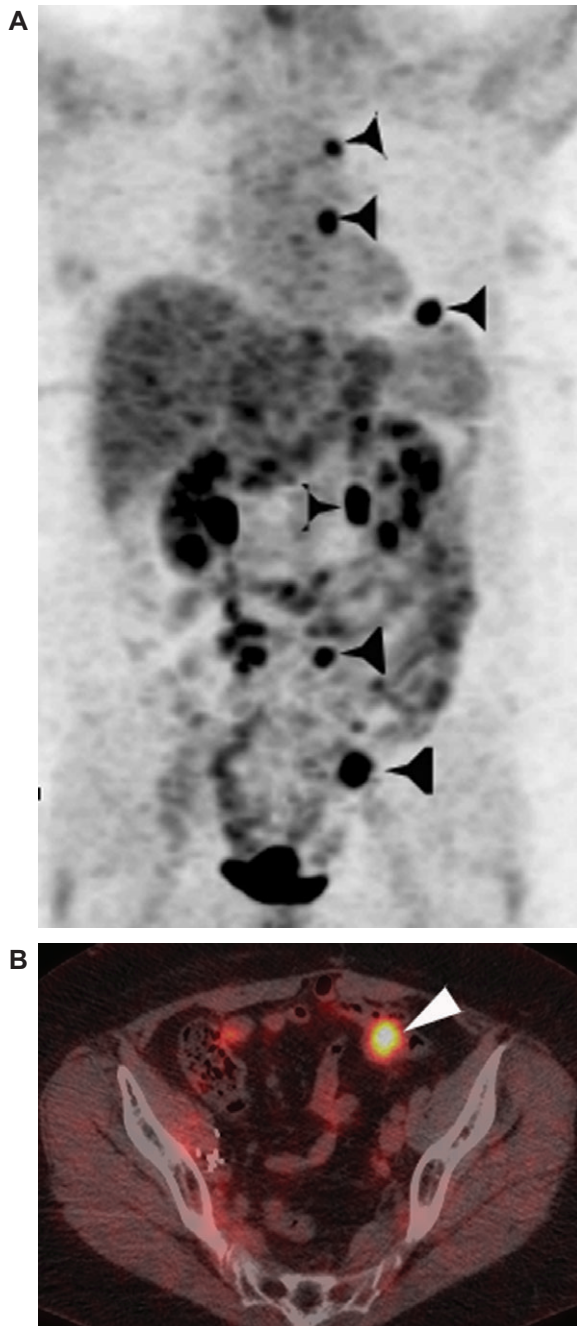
A 56-year-old female with recurrent ovarian cancer. (a) Coronal PET image shows multiple sites of FDG recurrent disease in the chest, abdomen and pelvis (arrowheads); (b) axial fused PET/CT localizes one site of FDG uptake to the sigmoid colon which proved to be metastatic ovarian cancer involving the colon.
